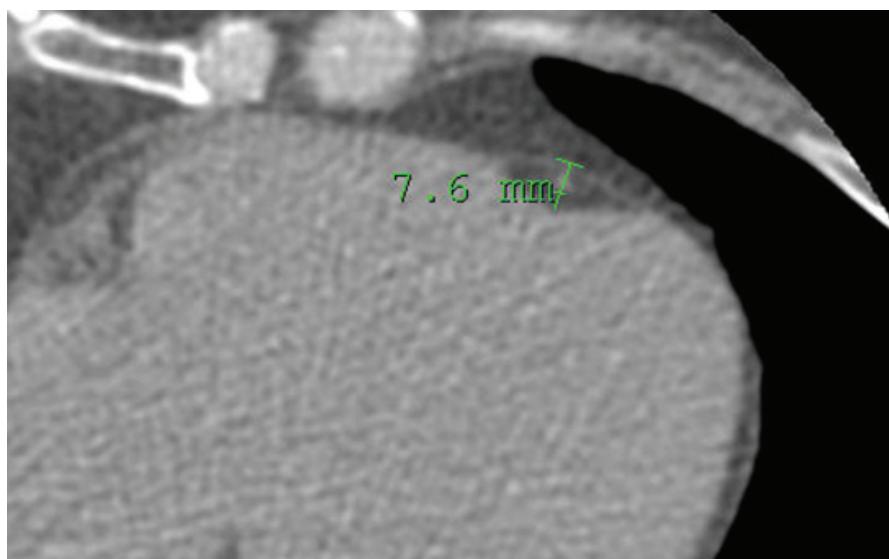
This multi-detector CT calcium scoring scan clearly shows the pericardium with underneath it the pericardial adipose tissue (EAT) surrounding the left anterior descending coronary artery (LAD). At this level the measurements of EAT in the LAD area can be done perpendicularly to the heart.
